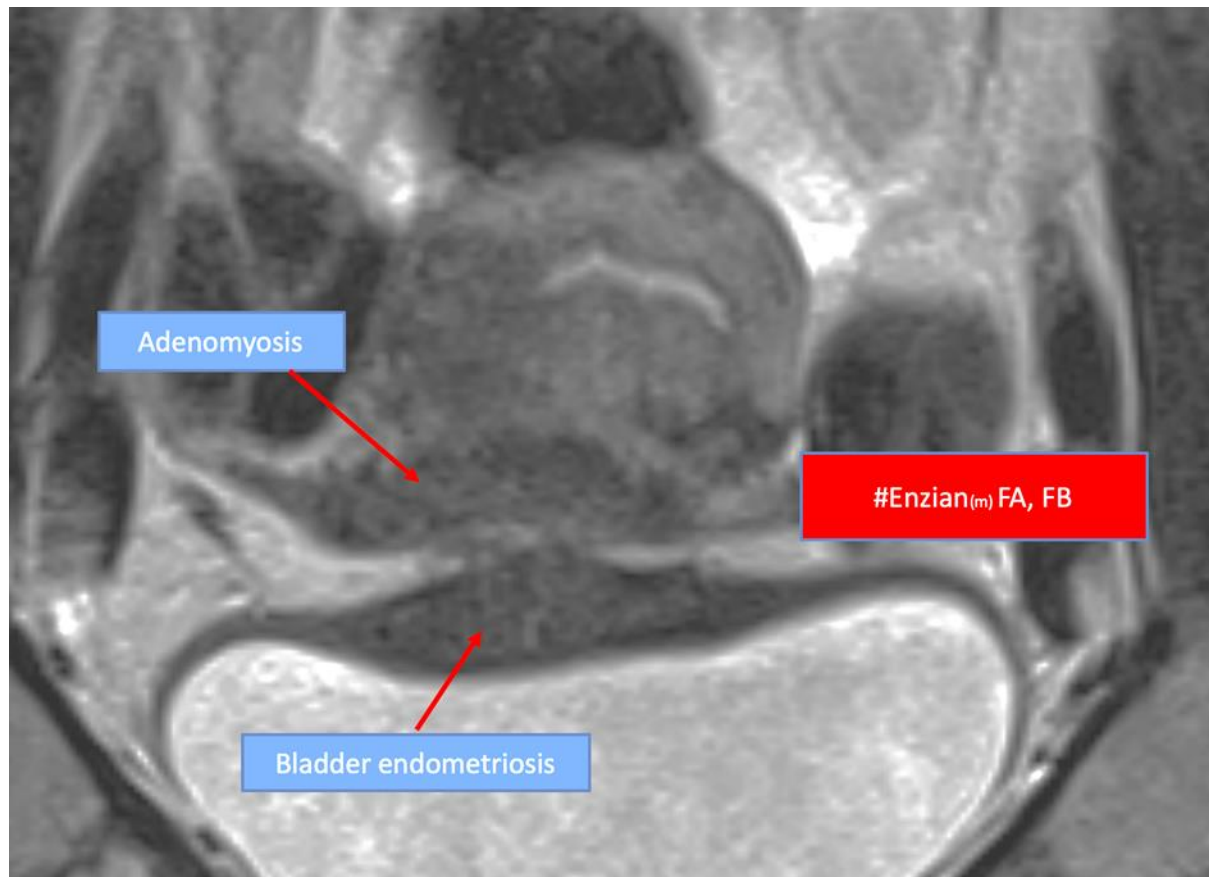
Example 2; MRI image showing adenomyosis and bladder wall endometriosis. FA: Adenomyosis, FB: Bladder endometriosis; Coding: #Enzian(m) FA, FB (Author I did put more contrast in the picture see if this is OKE for you)
